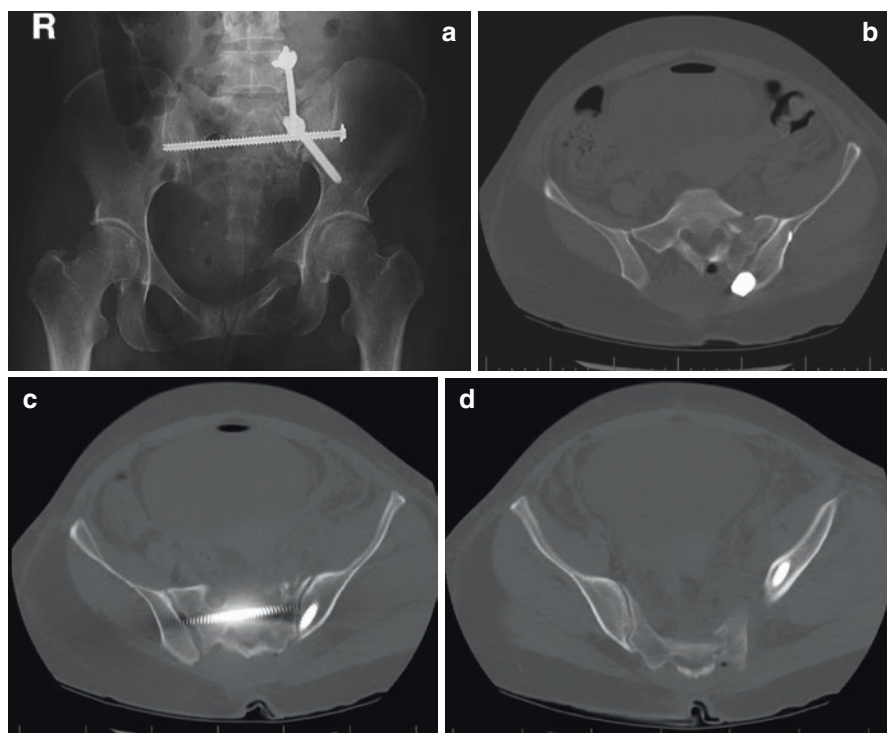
Post-operative radiograph (a) and CT (b–d) images depicting adjunct lumbopelvic fixation for comminuted pelvic ring injury. The iliac bolt traverses the ilium passed the transsacral screw and is affixed to the L5 pedicle screw without the need for a transconnector
